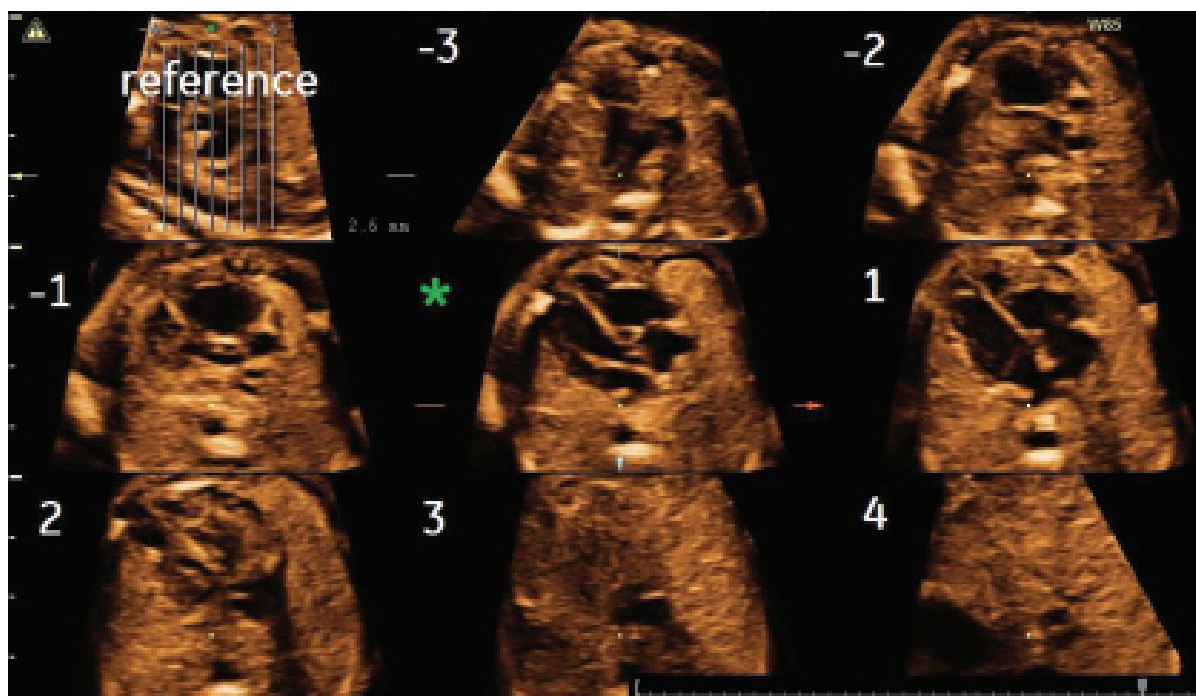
Tomographic ultrasound imaging in a STIC volume in diastole in a normal heart. In the top left section, the overlay image is presented, which is perpendicular to the tomographic layers, demonstrating section levels
